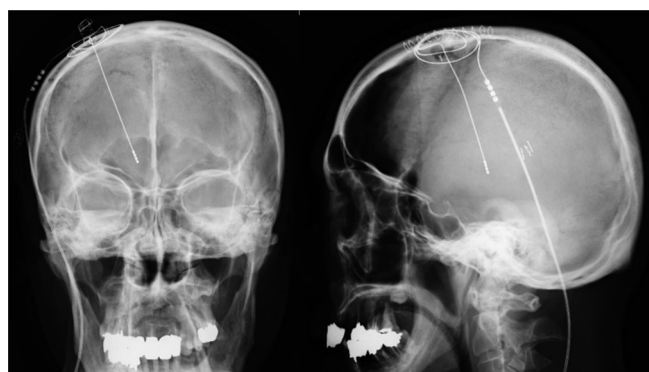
Cranial X-ray picture. The microelectrode was introduced to the right ventral intermediate nucleus. The position of the electrode tip was checked by the anterior-posterior view and lateral side view.
